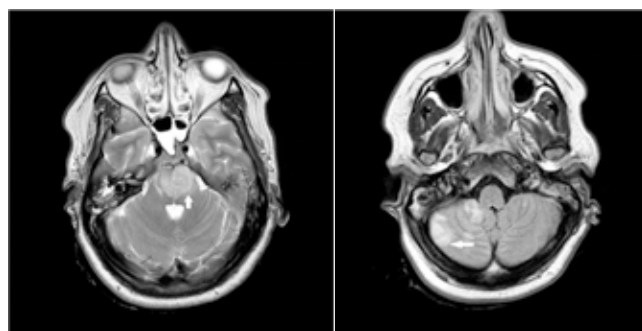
T2-weighted axial MRI brain demonstrating bilateral pontine and right cerebellar infarction (August 2008).
